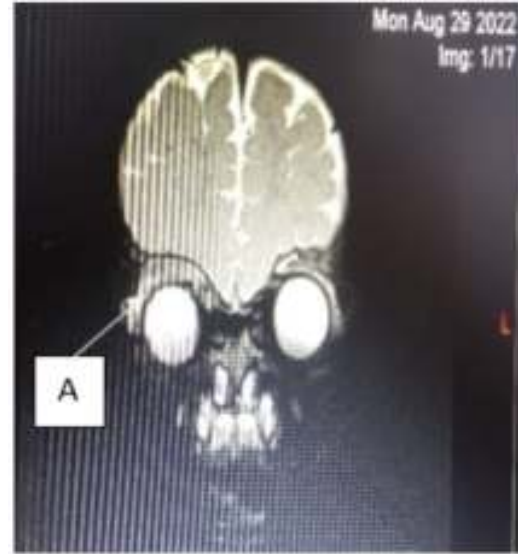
Magnetic resonance imaging of orbit and brain (A) shows extraconal thickening of superior aspect of right eye globe with associated thickening and enhancement of superior rectus-levator palpebrae superioris complex, highly suggesting inflammatory changes with parasitic granuloma
